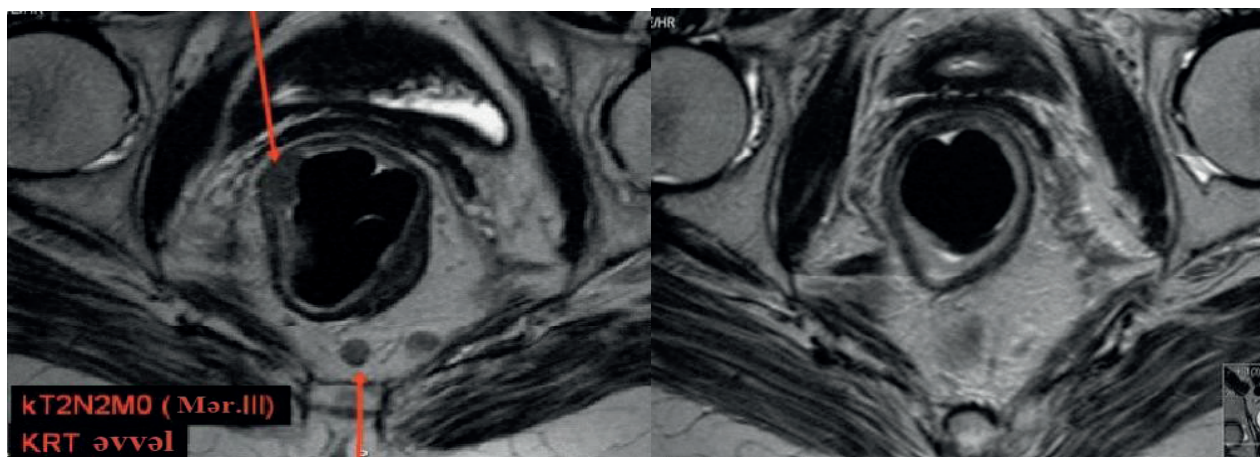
MRI images after radiotherapy
